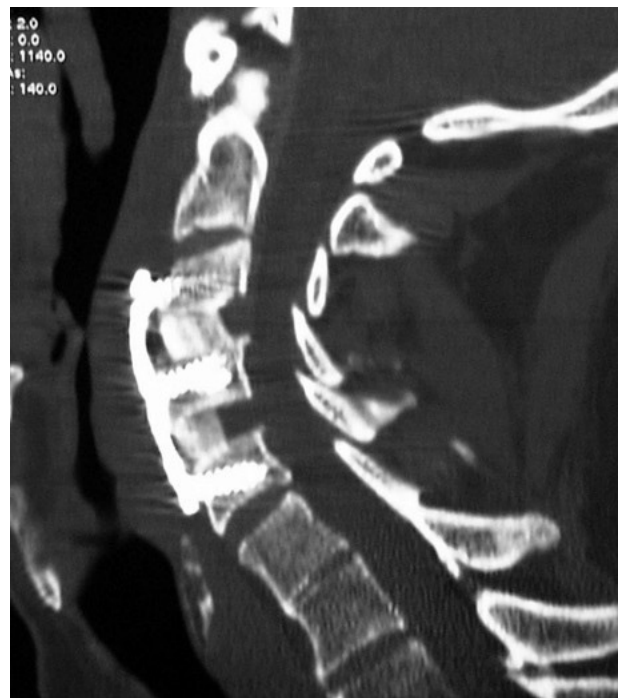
Computed tomographic image of a patient after 2-level anterior cervical discectomy and fusion with allograft.
